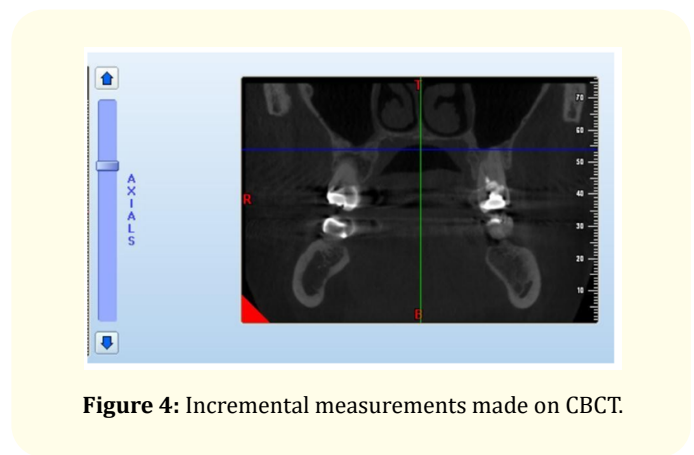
Incremental measurements made on CBCT.
